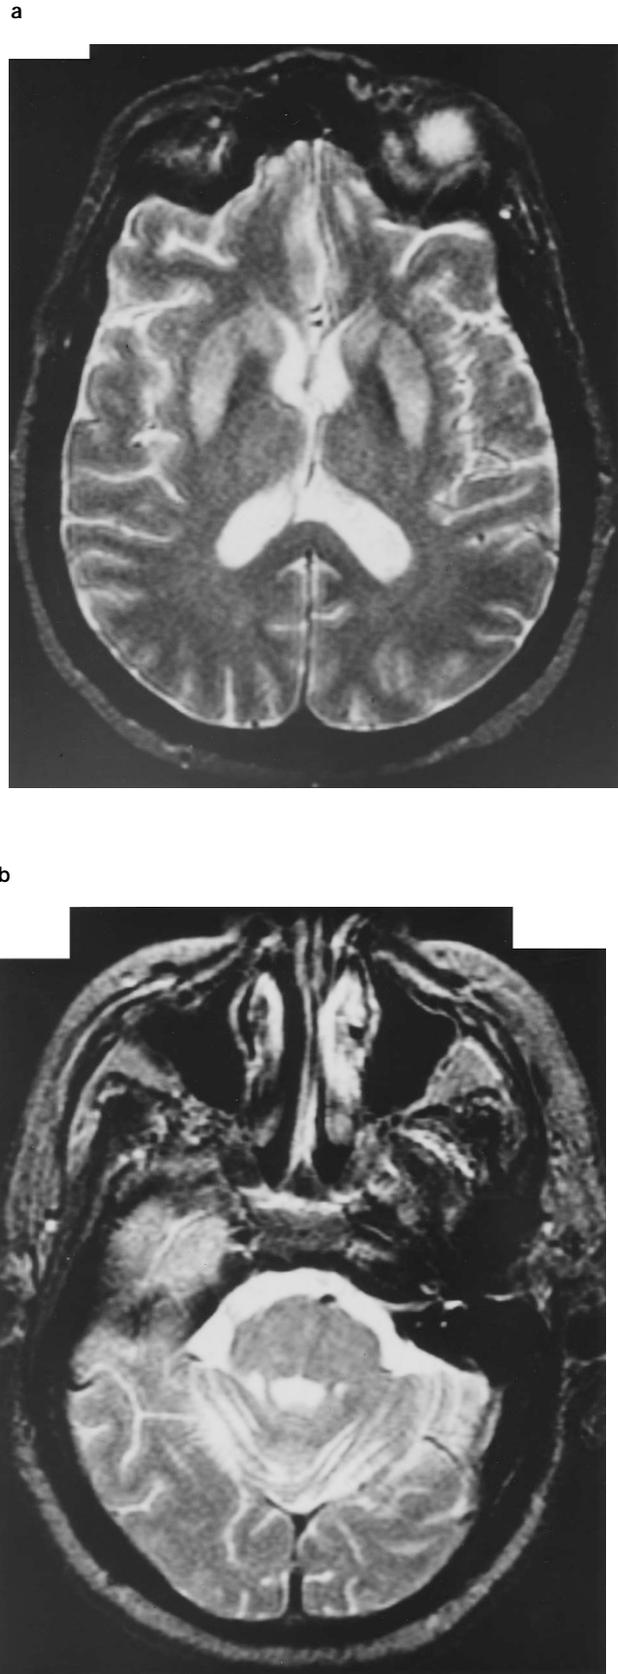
MRI T2 weighted images showing (a) enhancement in regions affected by EPM; (b) lack of involvement of pons
